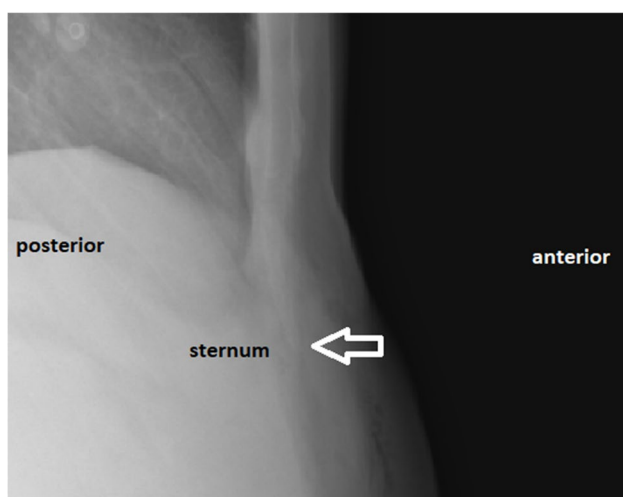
Postoperative lateral chest X-ray
